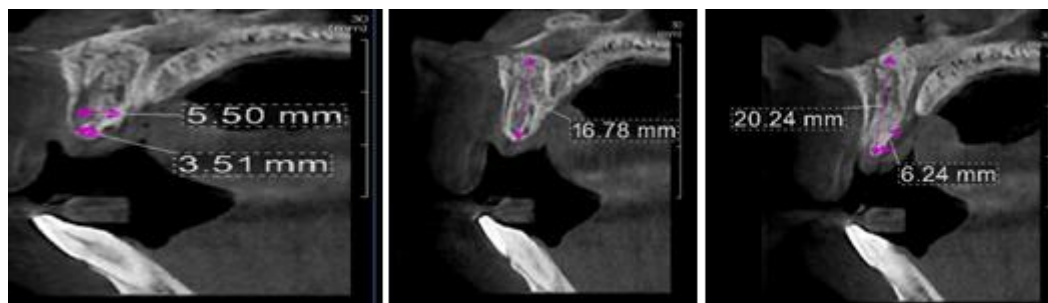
4 & 5: Preoperative CBCT
